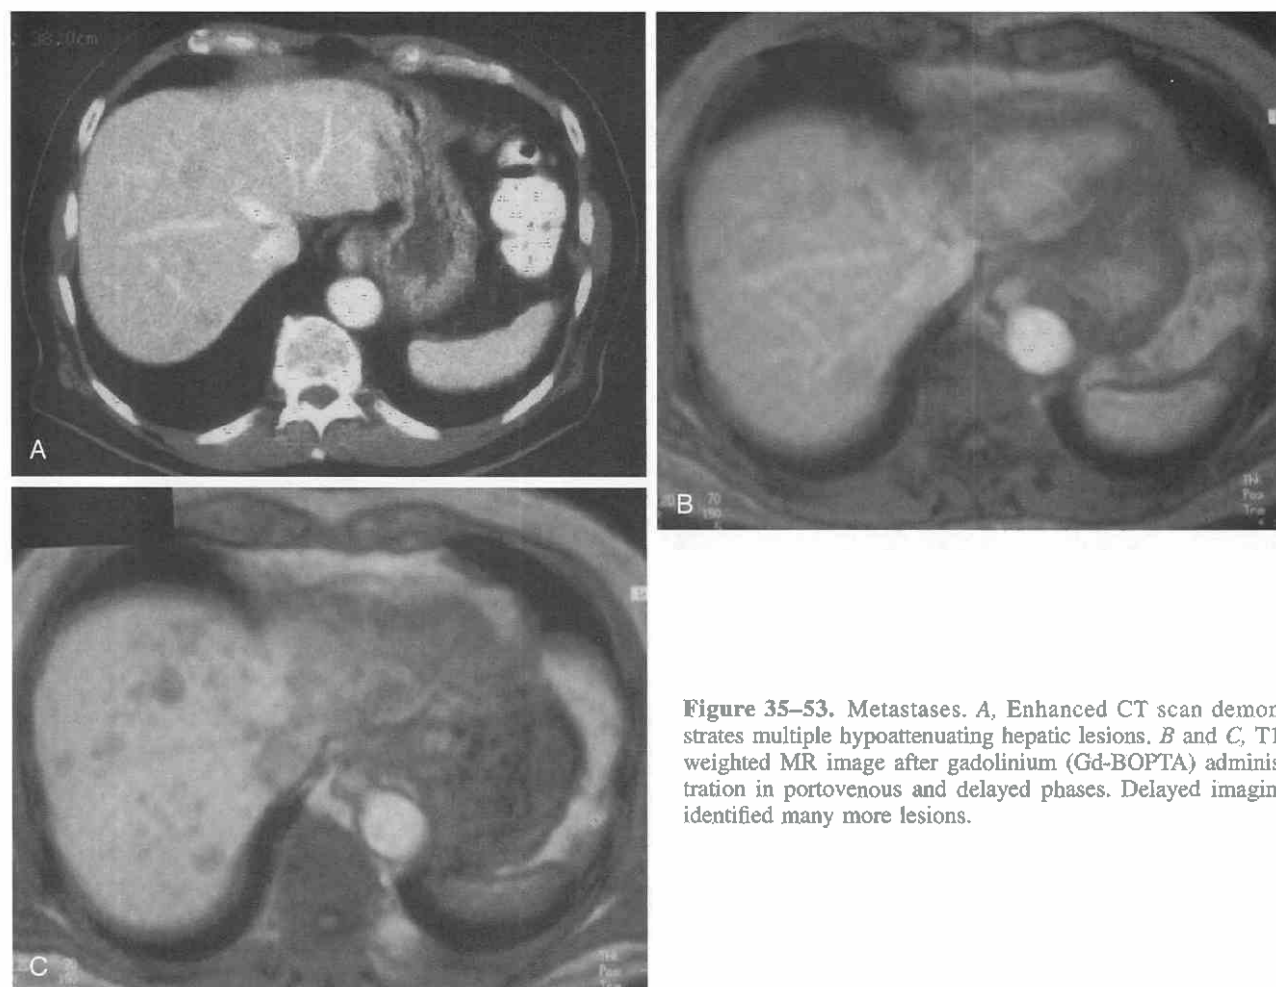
Metastases. *A*, Enhanced CT scan demonstrates multiple hypodense hepatic lesions. *B* and *C*, T1-weighted MR image after gadolinium (Gd-BOPTA) administration in portovenous and delayed phases. Delayed imaging identified many more lesions.
